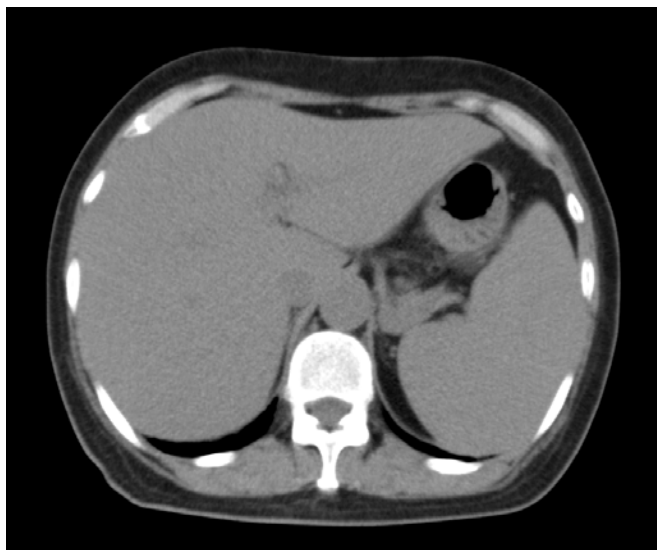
CT scan image shows an enlarged spleen.
